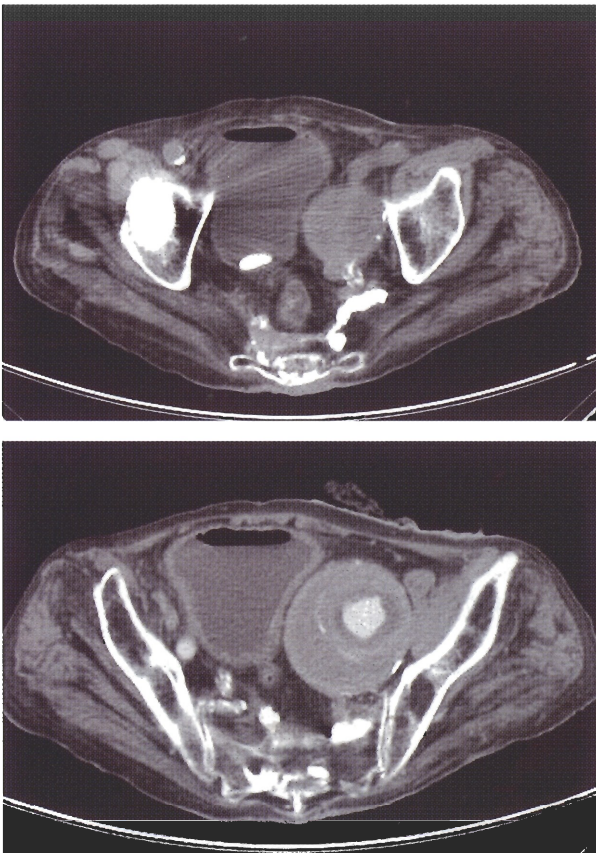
Pelvic enhanced CT
